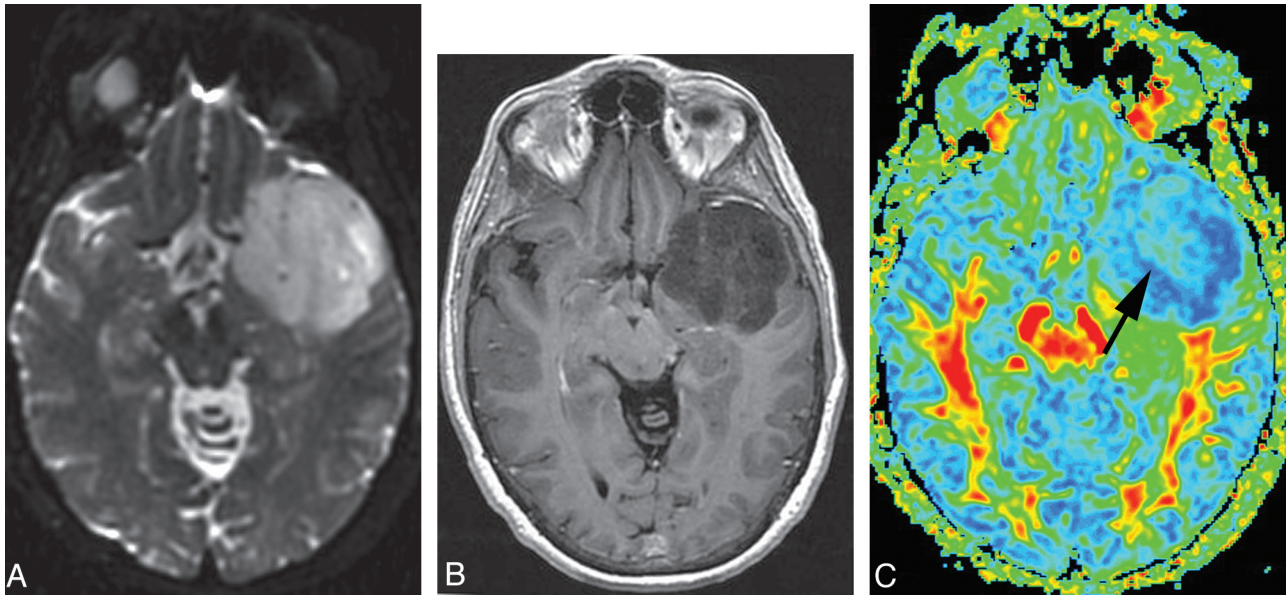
A, T2-weighted MR image shows a grade III glioma. B, Postgadolinium axial T1-weighted image does not show obvious tumor contrast enhancement. C, FA map shows that the tumor has a warmer color tone (light green [arrow]) compared with that in Fig 2. Maximum FA, minimum FA, FA range, and maximum SD are 0.170, 0.0794, 0.0906, and 0.0507, respectively. Each value of the measurements for this grade III tumor is correspondingly larger than that for the grade II tumor shown in Fig 2.
